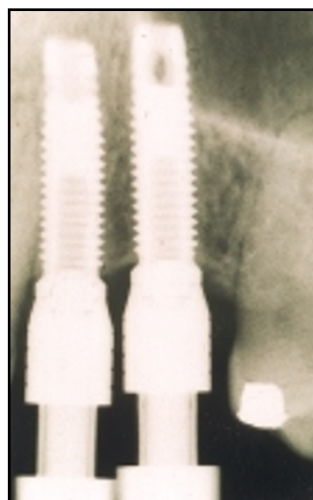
Radiograph of the head of implant impression copings in place to verify seating
